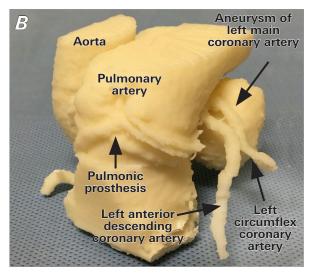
A) Computed tomography image shows the left main CAA and ascending aorta. B) Three-dimensional print of the anatomy shows the relationship between the pulmonary artery, the pulmonic valve, the aorta, and the coronary aneurysm. C) The pulmonary artery and pulmonic valve are removed to expose the aorta and aneurysm.
